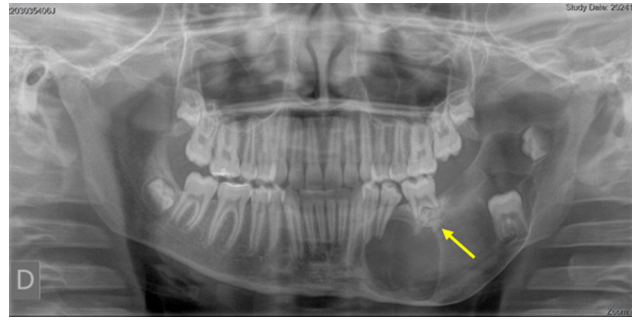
Orthopantomograph showing a lytic lesion with sclerotic edges located in the body and ramus of the left mandible. Displacement and separation of teeth 37 and 38. Root erosion in tooth 36 (yellow arrow).
